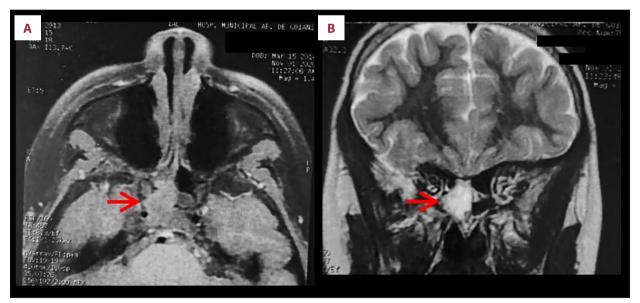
Magnetic resonance imaging. (A) Magnetic resonance imaging in axial T1 section. The red arrow points to a solid extensive/ infiltrative lesion in the sphenoid body, on the right side of the midline, occupying a large part of the sphenoid sinus and causing bone erosions on the posterior, lateral, and superior walls. There was also extension to the right cavernous sinus, where it involved about 180° of the cavernous segment of the right internal carotid. (B) Magnetic resonance imaging coronal T2 section. The red arrow indicates a solid extensive/infiltrative lesion in the sphenoid body, on the right side of the midline, occupying a large part of the sphenoid sinus, causing bone erosions on the posterior, lateral, and superior walls. There was also extension to the right cavernous sinus, where it involved about 180° of the cavernous segment of the right internal carotid artery.
